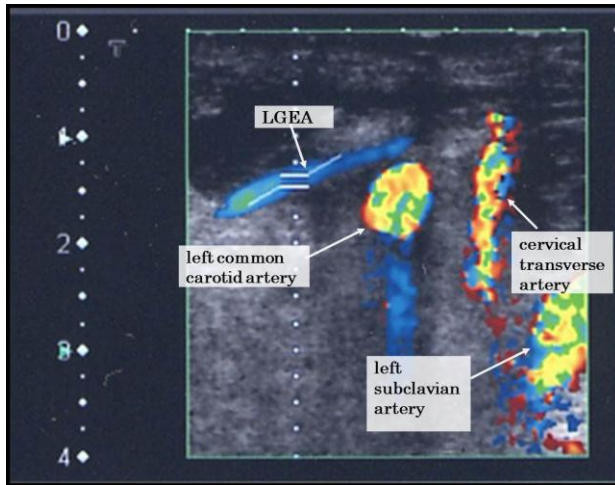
Ultrasonography.
